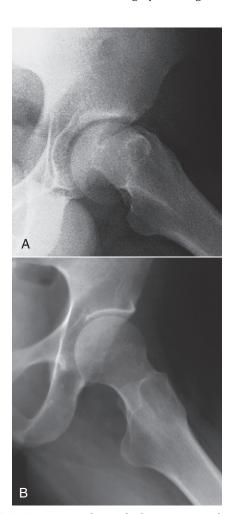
A, Hip radiograph demonstrating the mottled, grainy appearance associated with quantum mottle that results from the use of a low number of x-rays to produce the image. B, In comparison, an optimal hip image shows greater recorded detail. (Courtesy Tim Gienapp, Apollo College.)
